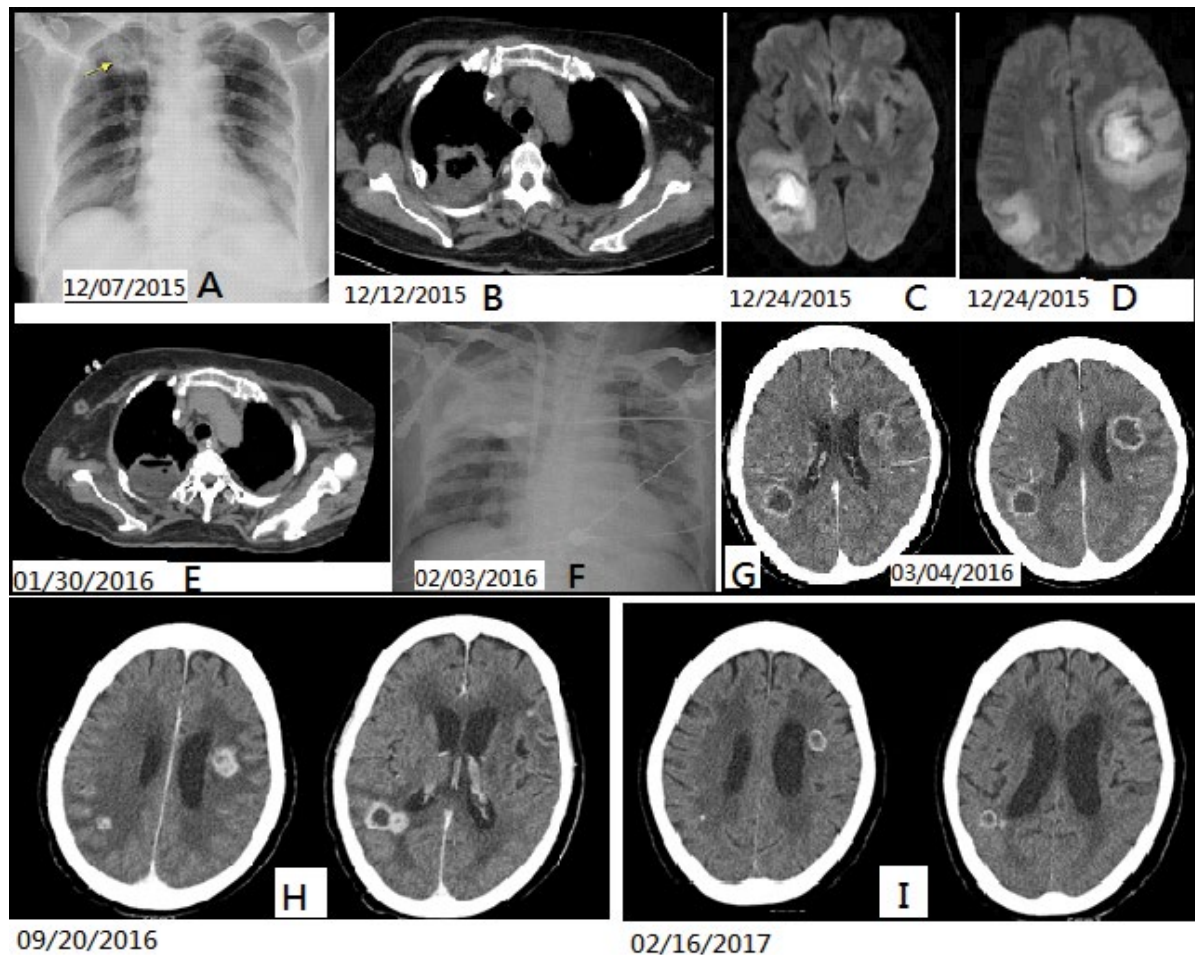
Chest X-ray film shows a nodular lesion in Right Upper Lung (RUL) field (A, arrow), which was suggestive of abscess formation by chest CT imaging; B) Brain MRI shows multiple hemorrhagic necrotic mass lesions, involving right temporoparietal and left frontotemporal regions; C,D) Follow-up chest CT scan shows persistent RUL lung abscess; E) Post-biopsy CXR shows consolidation over RUL; F) Indicating pulmonary hemorrhage clinically. Follow-up brain CT scans in post-voriconazole treatment; G,H) Subsequent posaconazole therapy (I) Show significant resolution of brain lesions, favoring cerebral aspergillosis.
